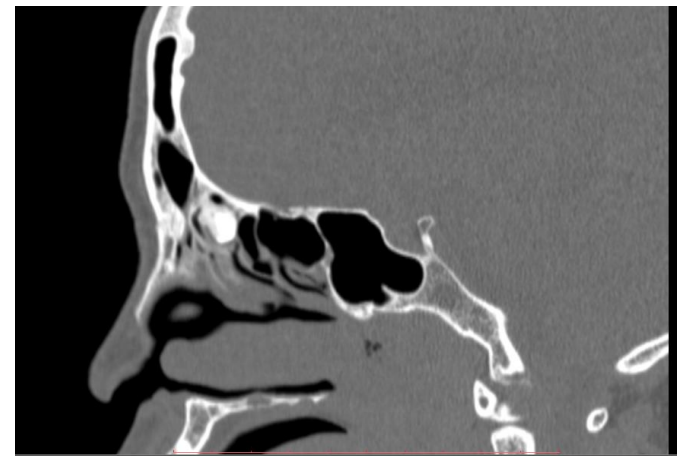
Sagittal reformatted CT of the paranasal sinus showing an osteoma of the ethmoidal sinus
